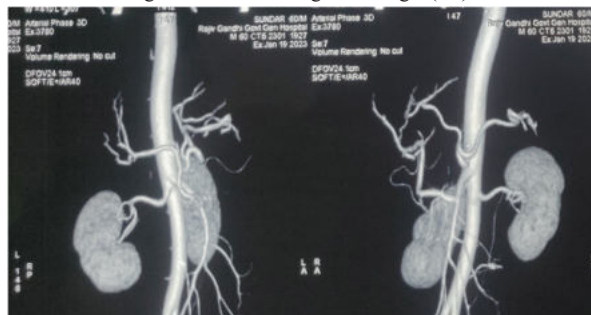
CT Angio abdomen showing RCHA and ALHA.
